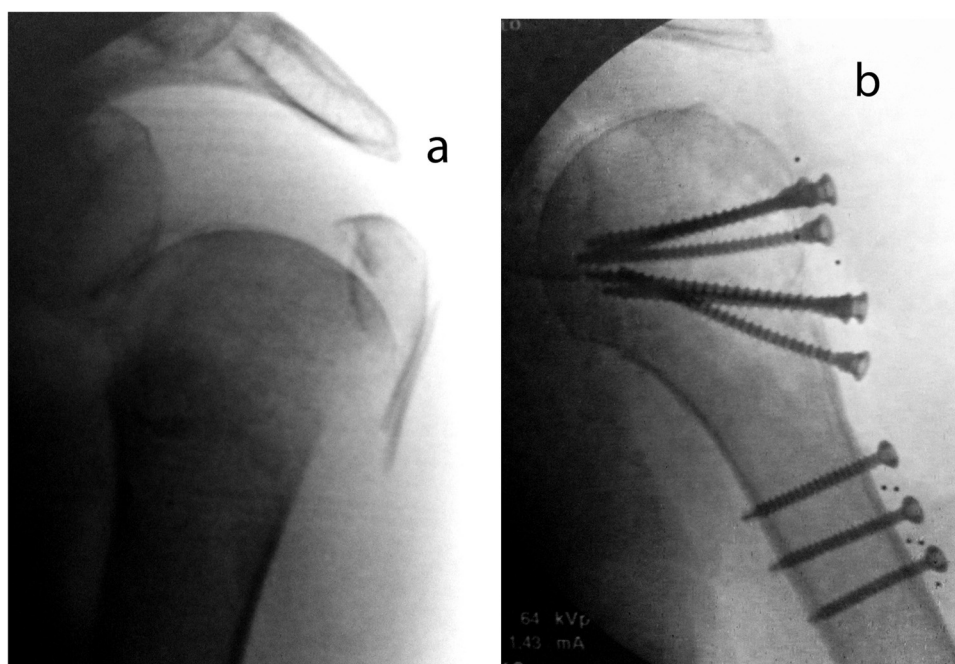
Hertel 7 proximal humeral fracture in a 59-year-old female treated with Diphos. a) Preoperative and b) Postoperative X-Rays.
